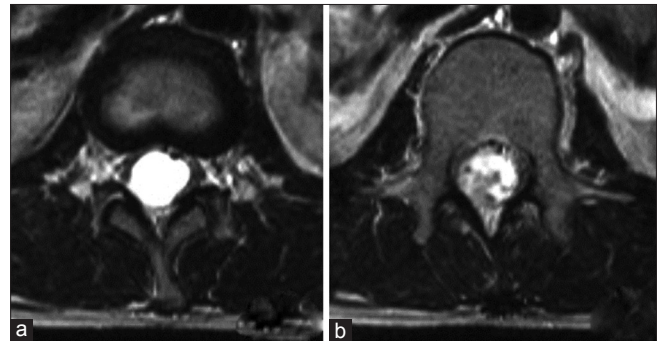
T2-weighted axial magnetic resonance images, T12-L1 intervertebral disc level (a) and L1 vertebral body level (b). Peritumoral cyst was evident
